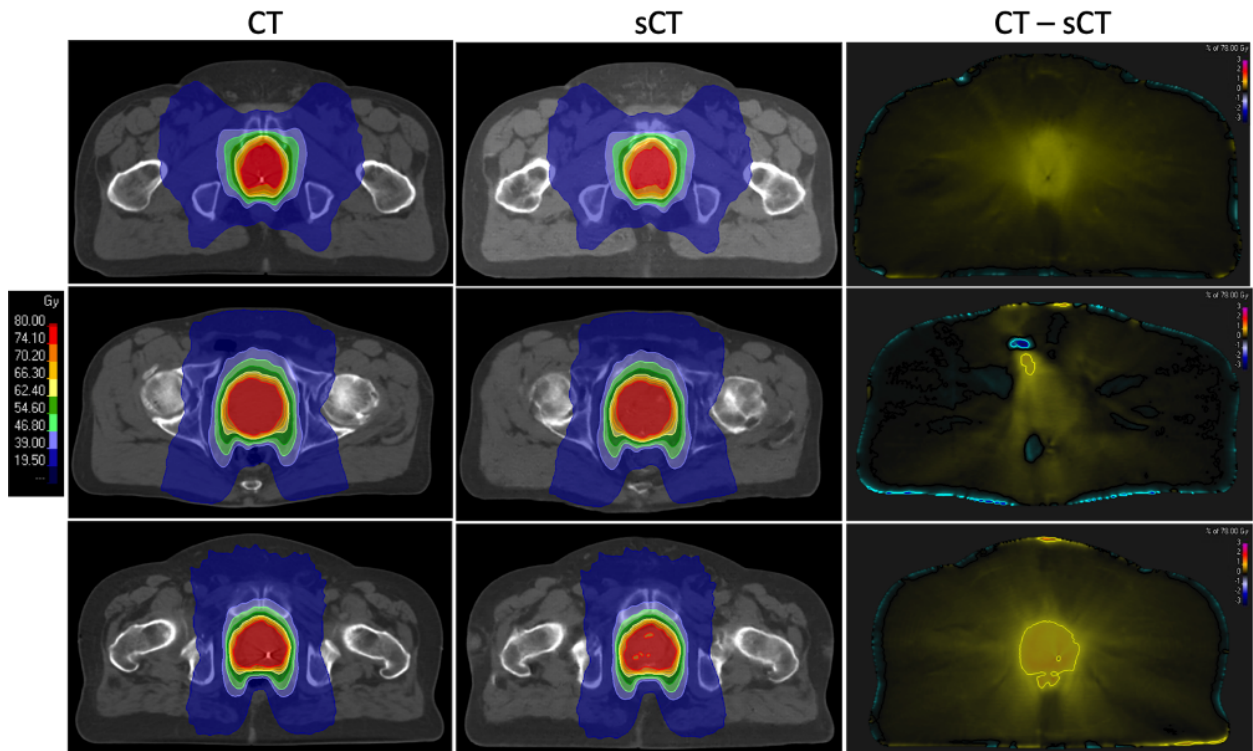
From left to right, dose calculated on CT, sCT and dose difference (CT - sCT).
